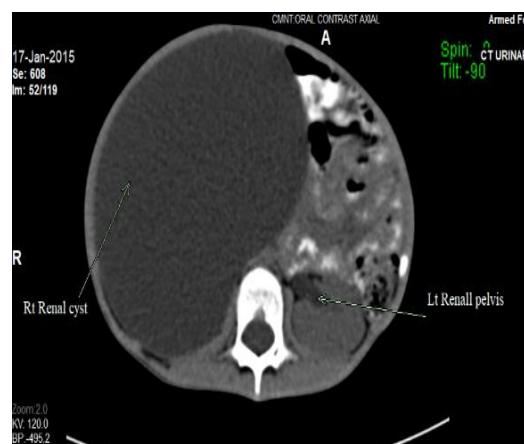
Axial view (B) CT scan urinary tract before surgery
